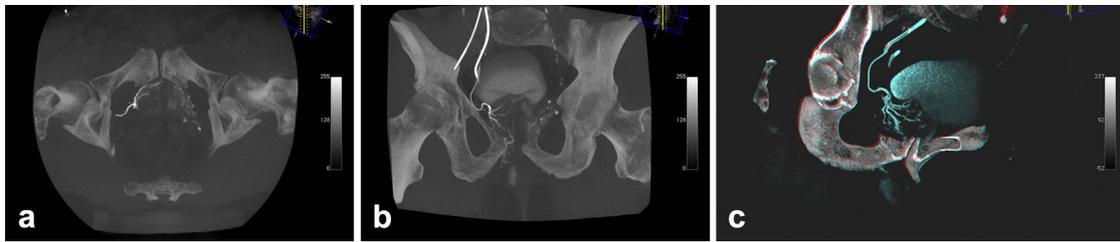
Cone-beam CT images after selective catheterization of the right prostate artery in the same patient shown in [Figure 1](#). Axial (a), coronal (b), and sagittal (c) reformatted images.
